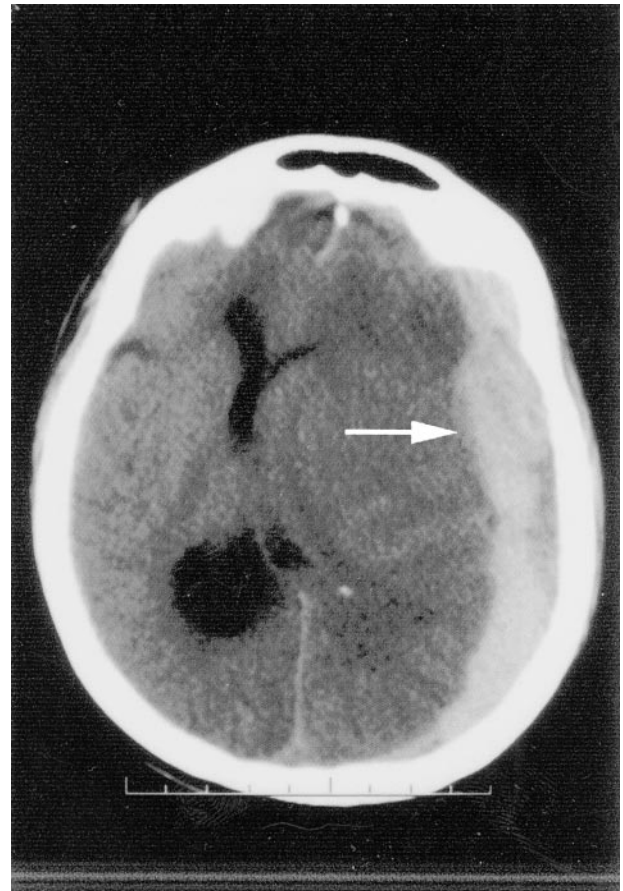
CT scan demonstrating a large right subdural hematoma with midline shift (arrow).
